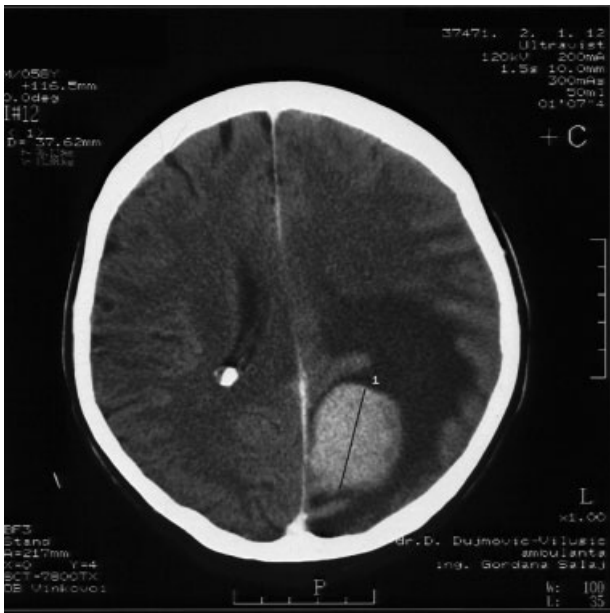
Preoperative contrast-enhanced axial computerized tomography (CT) scan demonstrated a well-defined supratentorial homogeneous mass lesion located parasagittally in the left occipital lobe with peritumoral edema and no leptomeningeal involvement.
